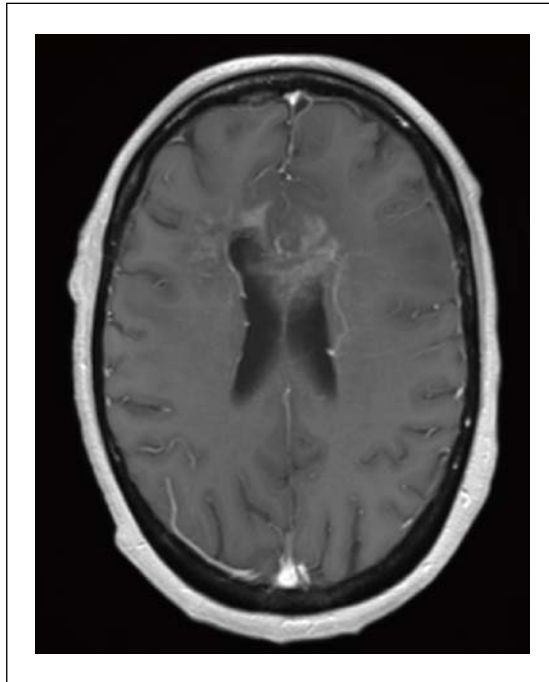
T1 post gadolinium sequence of magnetic resonance imaging (MRI) of a 46-year-old patient with a butterfly glioblastoma multiforme (GBM) invading the corpus callosum.
